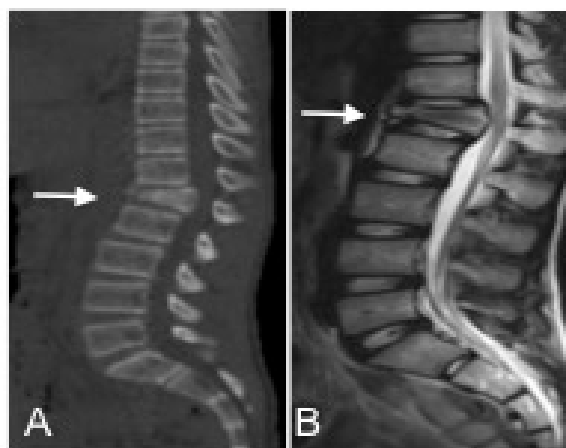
A 4 year-old boy patient with fracture of L1 after motor vehicle accident (white arrow). (A) Sagittal computerized tomography image, (B) Sagittal T2 weight magnetic resonance image.
